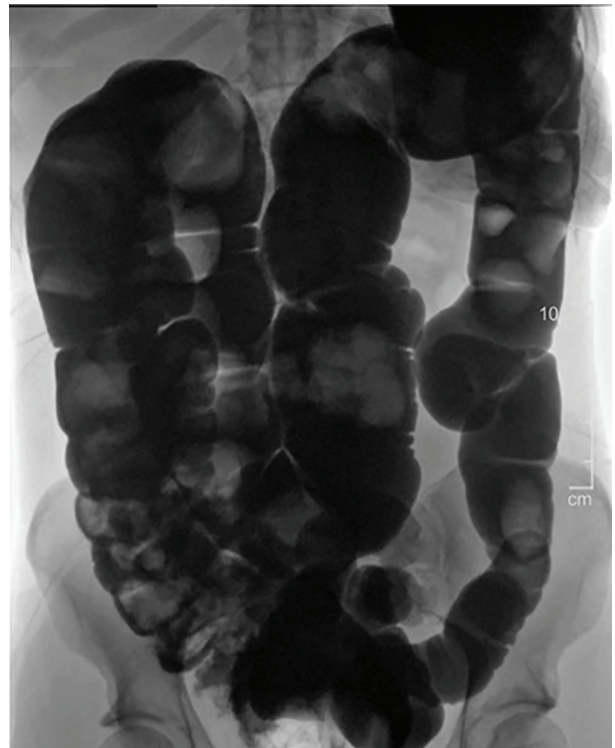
CT Diatrizoate meglumine (DM) enema with air contrast. DM flows retrograde from the rectum to the cecum without evidence of obstruction or mass. (Image credit: Reused from Brown et al. doi : 10.1093/jscr/rjad565. under the terms of the Creative Commons Attribution License, which permits unrestricted use, distribution, and reproduction in any medium, provided the original work is properly cited.)
